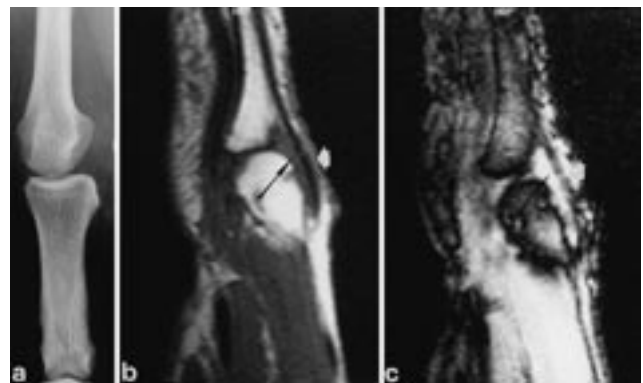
(a) The radiography of the IV metacarpo-phalangeal shows a joint effusion; however, it is not clear if there is also periarticular involvement. (b), (c) The MR images show a periarticular effusion (black arrows) with subcutaneous fat involvement (white arrows), hypointense in the T1W sagittal section (b) and hyperintense in the T2W (c).
